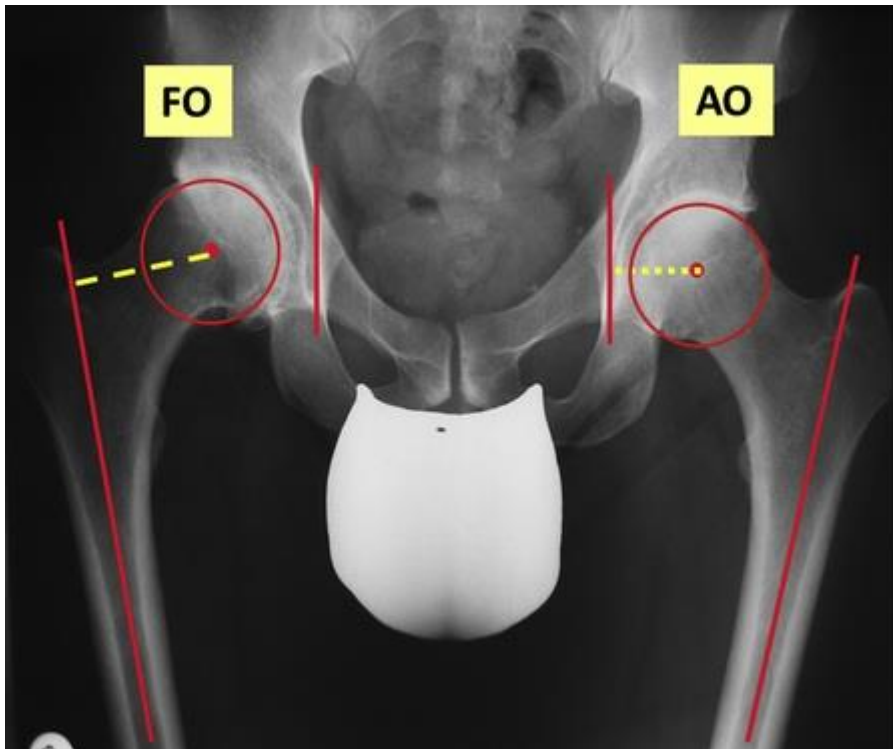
AP pelvis radiograph. AO, acetabular offset; FO, femoral offset; AP, anteroposterior.
